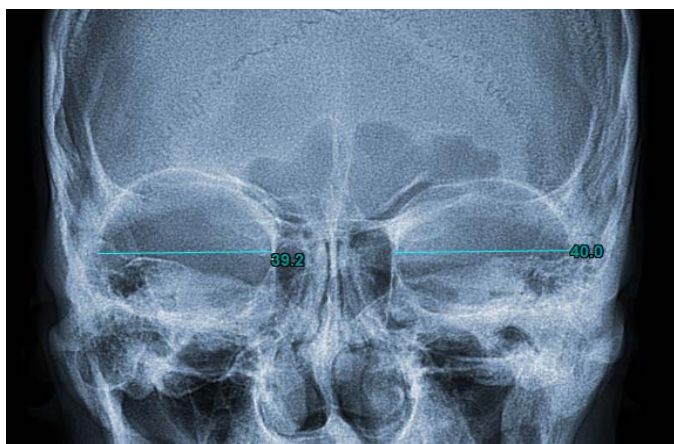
orbital width measurements of same patient on postero-anterior radiographs using Newtom digital software
